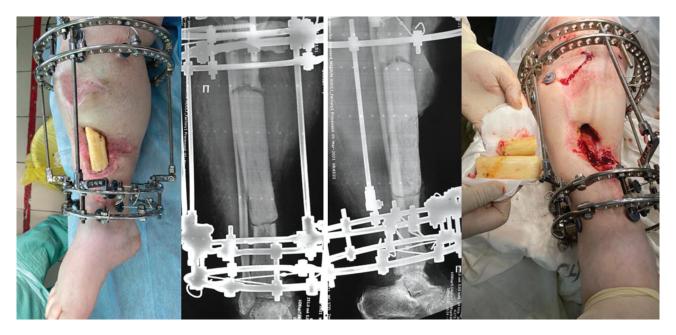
Photos and radiographs of female patient M before implantation and after removal of the spacer
